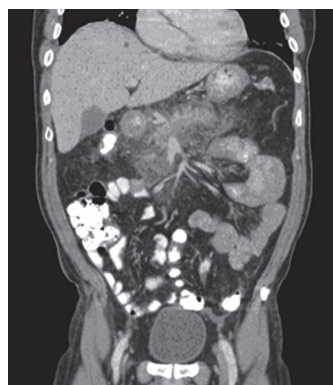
A transversal CT-image of a 54-year old male, who developed post-DBE pancreatitis (case 4), showing edema and fatty infiltration around the pancreas.
